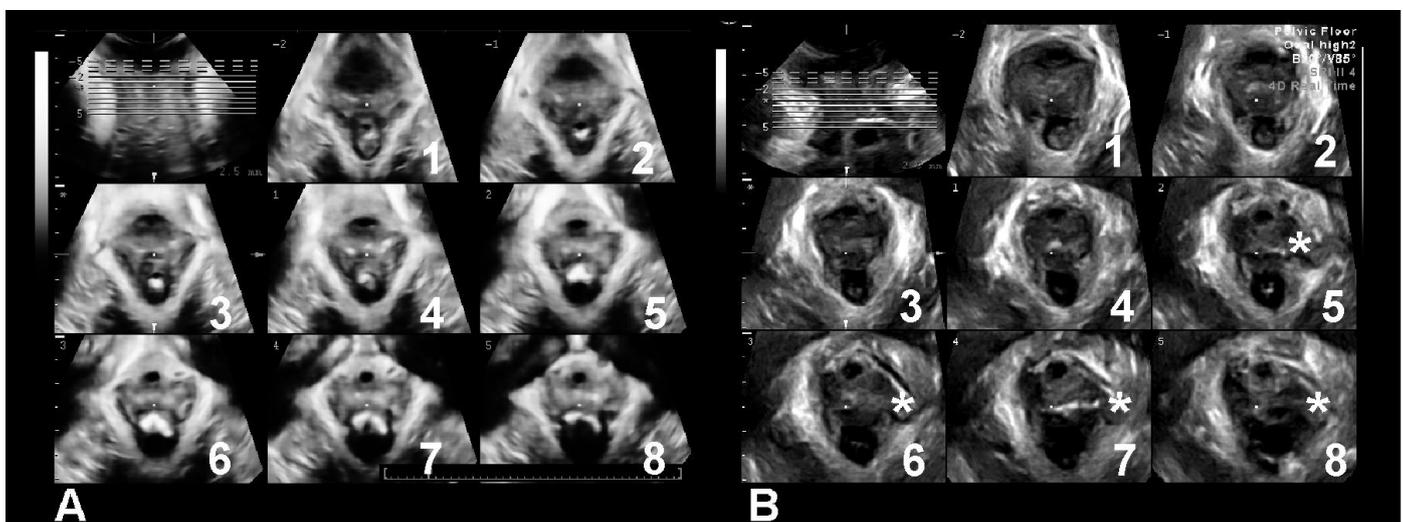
Tomographic or 'multislice' ultrasound images of a normal pelvic floor (A) and a minor form of unilateral trauma (B) visible in slices 5-8. On palpation the hiatus itself was intact, as was the insertion of the puborectalis on the inferior pubic ramus, but there was a gap in the puborectalis in the region of the obturator foramen, implying detachment of the muscle from the arcus tendineus.
